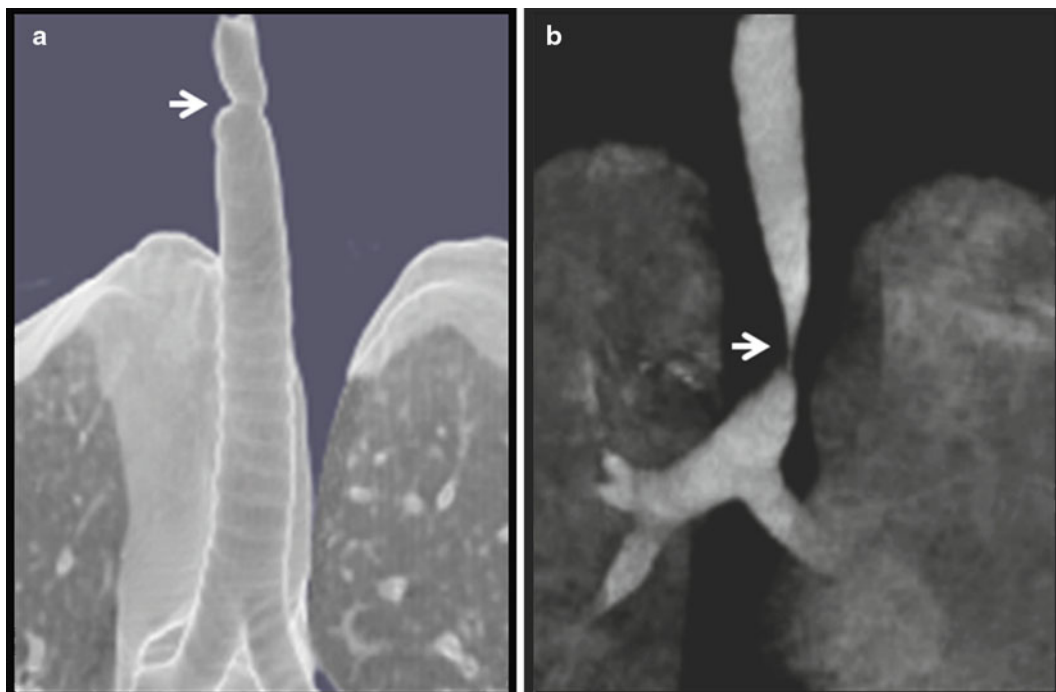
Three-dimensional reconstruction computed tomography imaging showing (a) abrupt and (b) tapered transition zone
